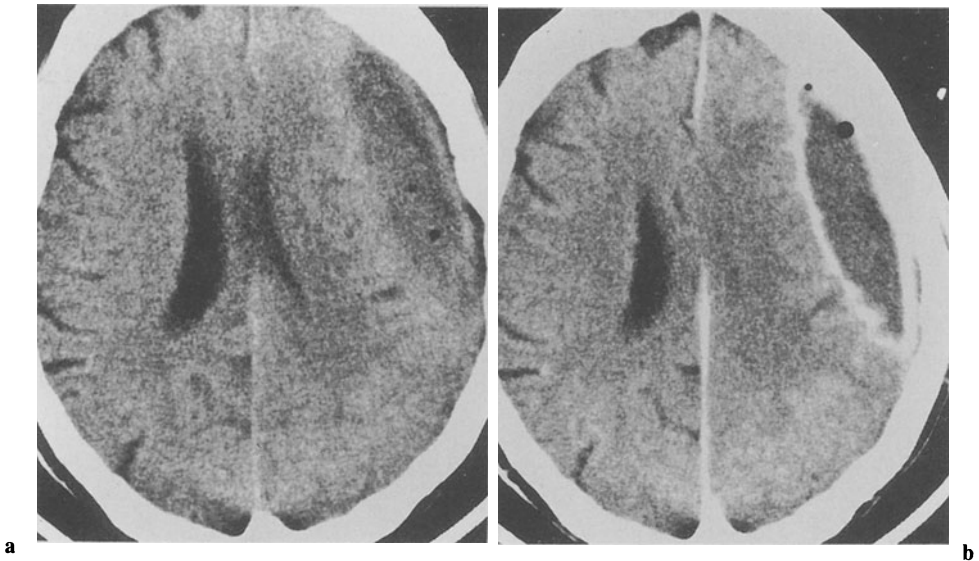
Subdural empyema in a 70-year-old man with a changed mental status occurring 4 weeks after drainage of a chronic subdural hematoma through a burr hole. Axial CT scans obtained before (a) and after (b) IV administration of iodinated contrast material reveal extraaxial mass lesion of low density compared with normal brain parenchyma that is biconvex and enhances peripherally, with short extensions of the enhancement into several sulci. The ipsilateral ventricle is largely compressed due to the mass effect. (Courtesy of Klaus Sartor and Marius Hartmann, Heidelberg)
